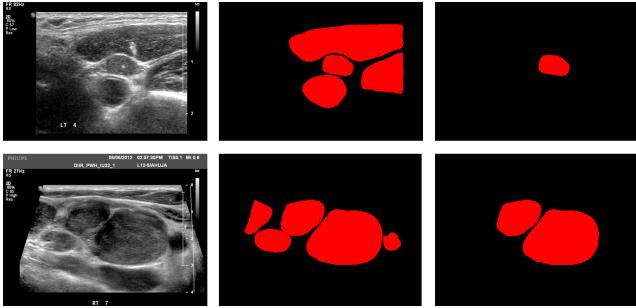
Left column: input images; middle column: intermediate label maps (marked by a non-expert, the desired output of FCN A); right column: final label maps (marked by an experienced sonographer, the desired output of FCN B).
